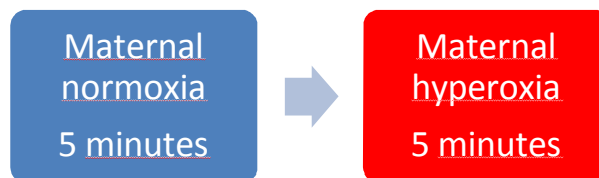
The protocol of the maternal oxygen supply during the BOLD MRI scan in the human placental study.
